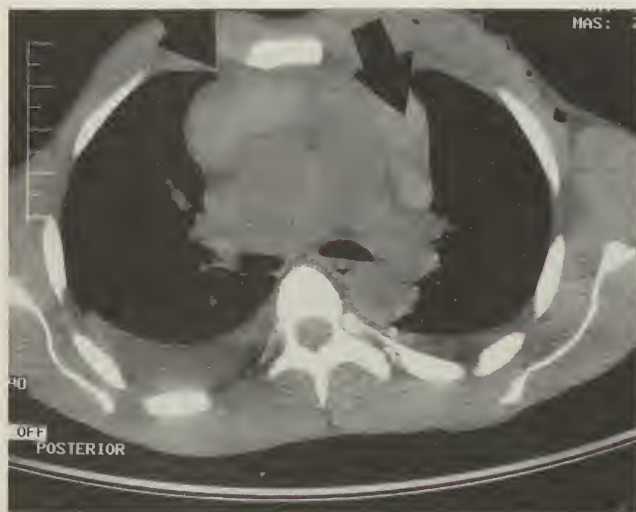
CT of chest. There is posterior displacement of the trachea by a large anterior mediastinal density. The base of the heart is posteriorly displaced. The air-filled esophagus is seen behind the left main bronchus. A right pleural effusion is present.
